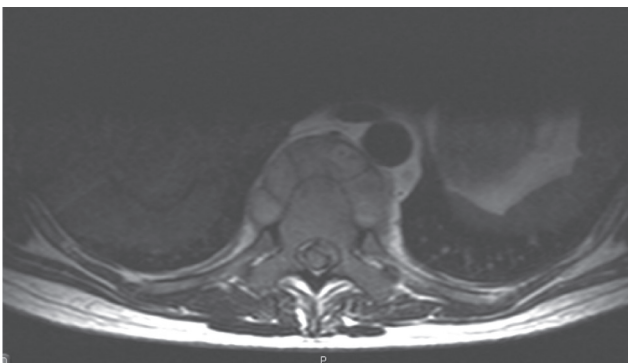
MRI before treatment. Spondylodiscitis T6-T10, area of necrosis, peripheral contrast enhancement and an epidural component. There was also pathological fracture of T10.
